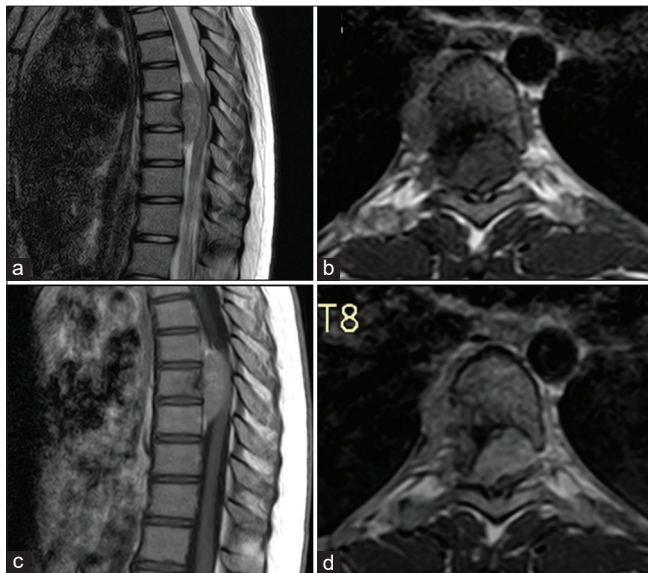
Spinal magnetic resonance imaging (a and b) showing extra axial mass from T7 to T9 compresses the spinal cord isointense in T1WI, high signal after gadolinium injection (c and d).
